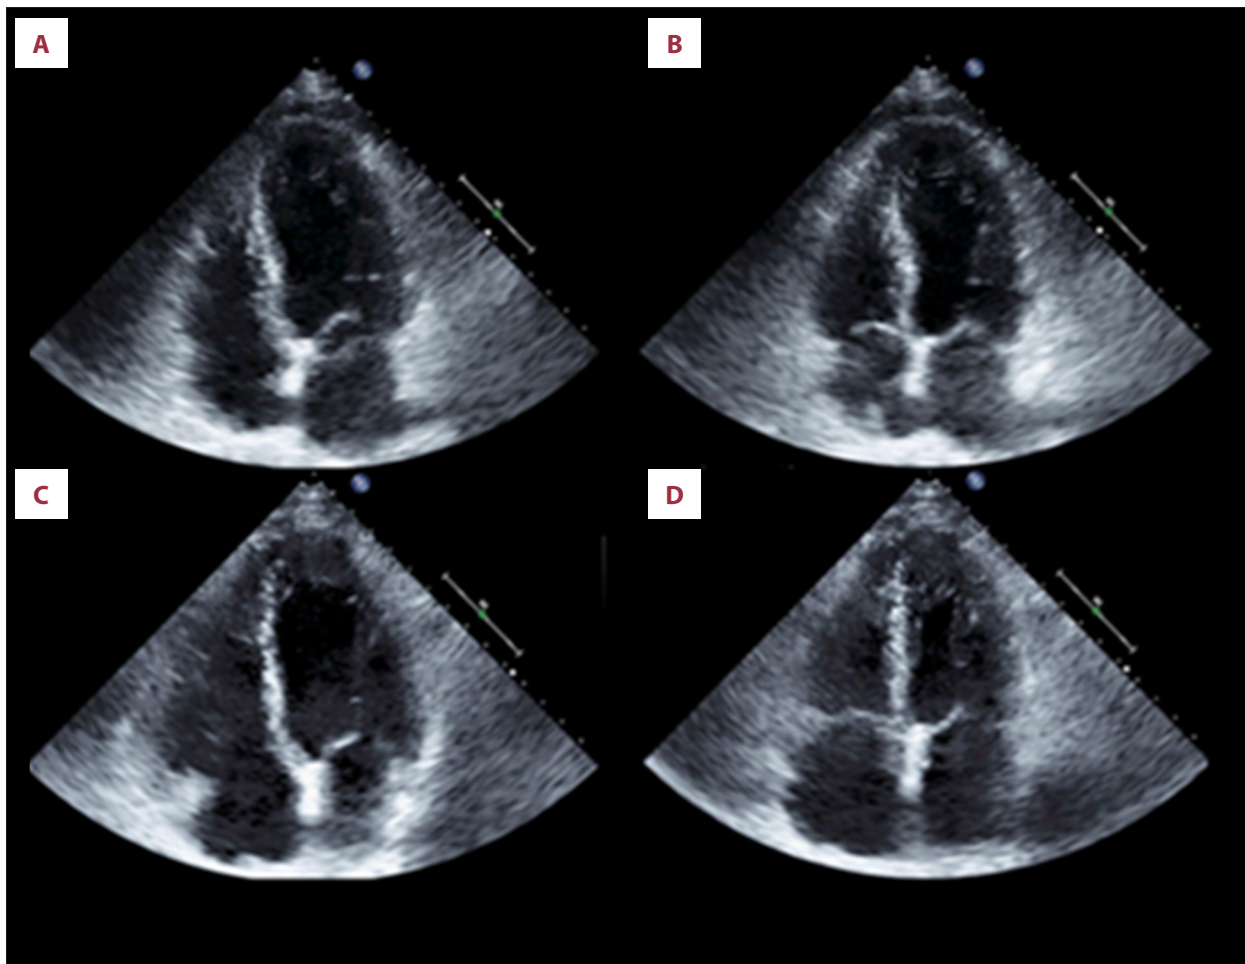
Initial echocardiogram showing apical ballooning during diastole (A) and systole (B) in the 4-chamber view. Repeat echocardiogram 8 weeks after discharge showing resolution of the apical ballooning during diastole (C) and systole (D) in the 4-chamber view.
